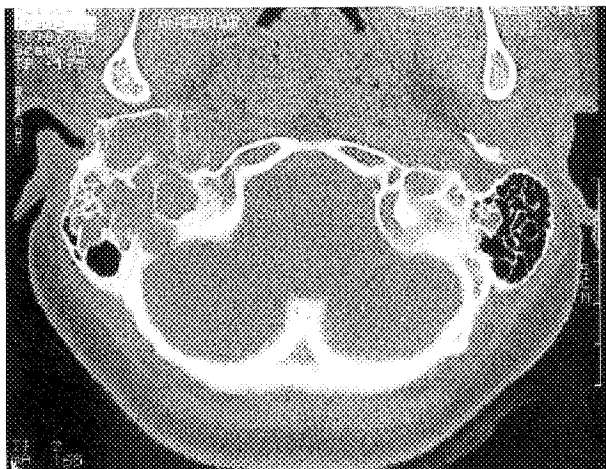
Axial CT scan (case 2) with obliteration of right external auditory canal, mastoid, and hypotympanic region by cystic fibrous dysplasia.
